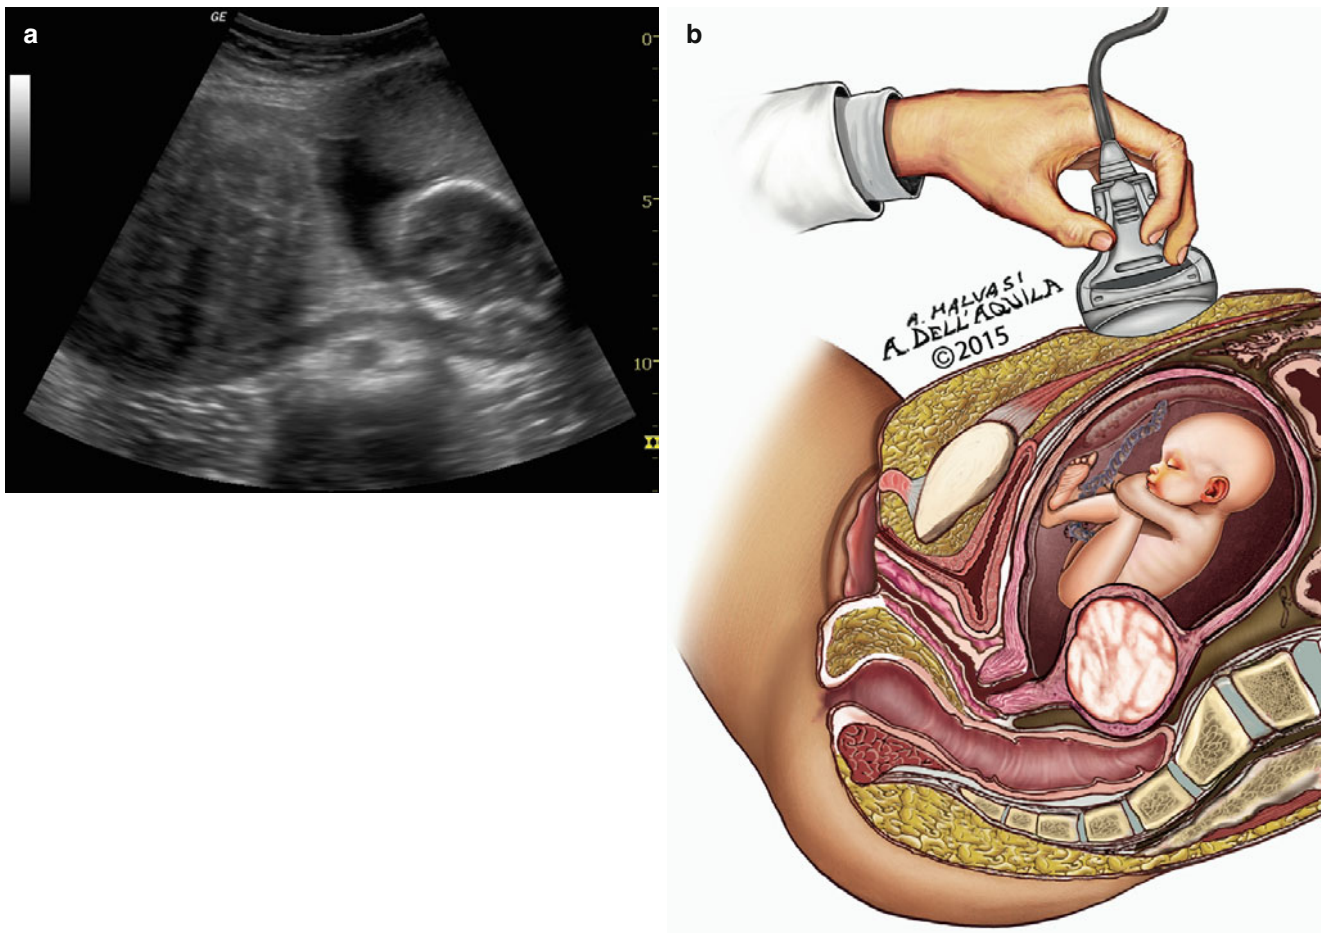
An ultrasonographic scan showing a fetus at 18 weeks in a uterus with an anterior placenta and a posterior fibroid of 8 cm in diameter (a); the draft shows a fetus at 15 weeks in a uterus with anterior placenta and posterior uterine fibroid
